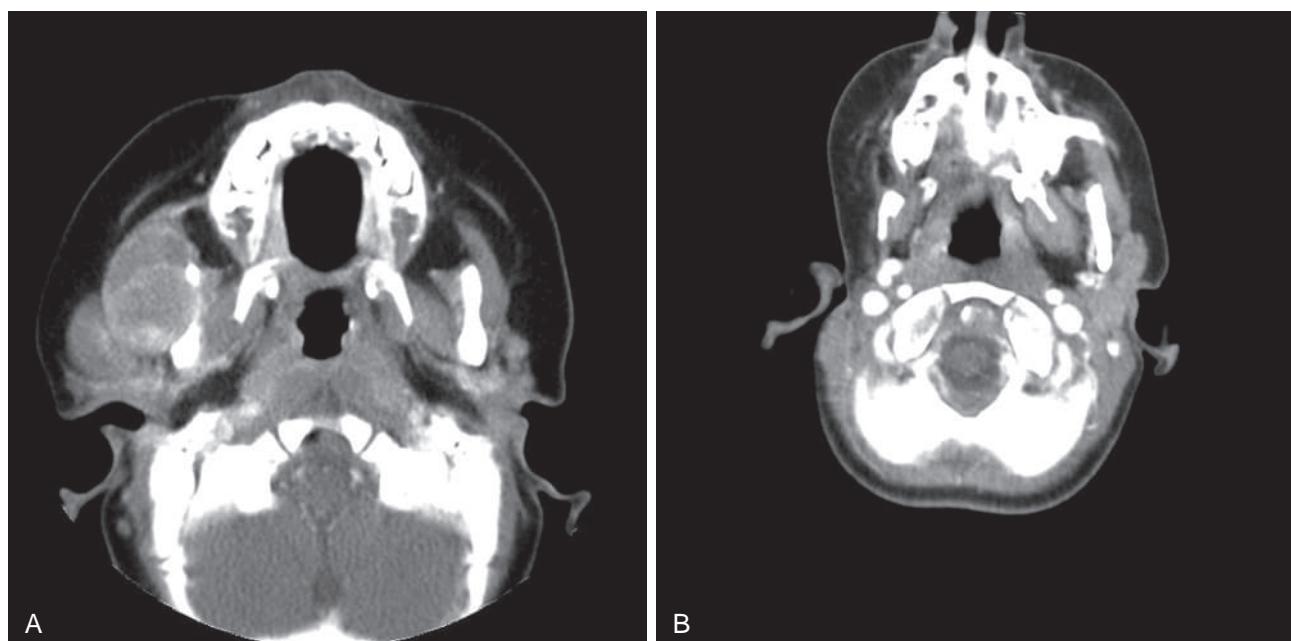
Late effects of radiation. (A) Computed tomography (CT) image showing rhabdomyosarcoma of the right masseter muscle. (B) CT image of the same patient 3 years after chemotherapy and radiation showing hypoplasia of the right mandible. (Courtesy Dr. Terry Vik.)
